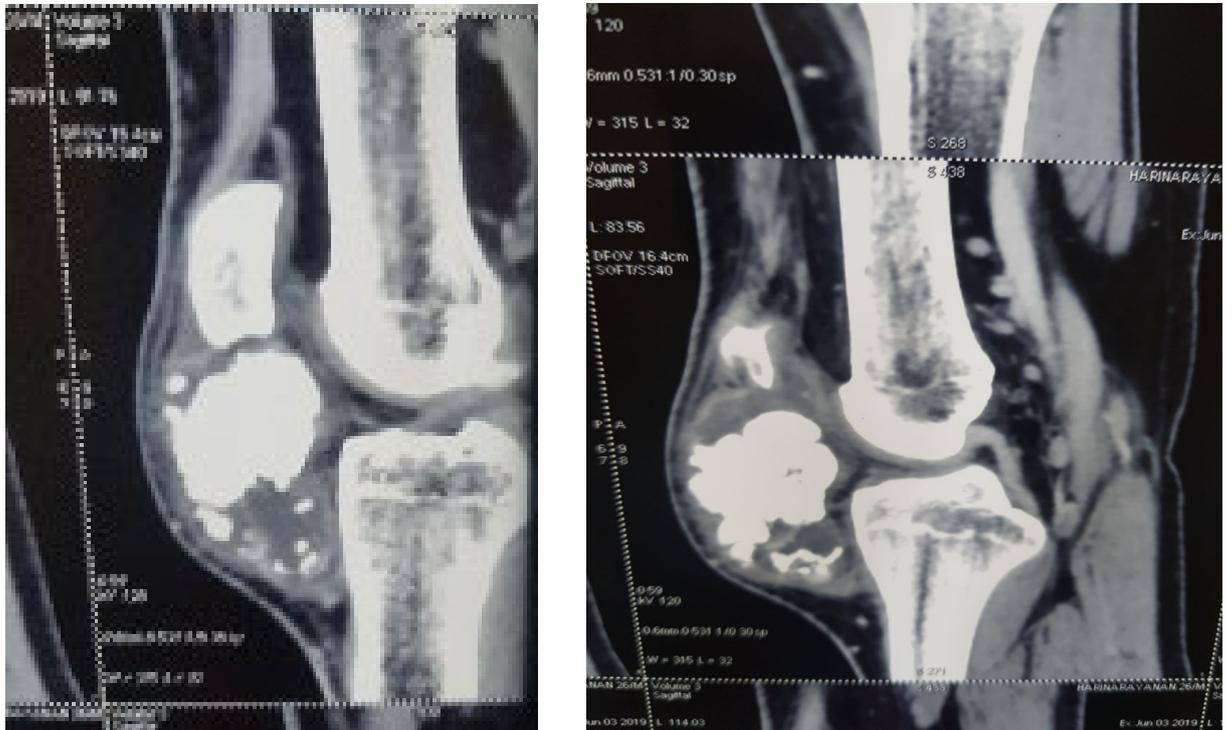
Saggital CT image of left knee showing an extraskeletal para articular osteochondroma arising from the Hoffa's fat pad
